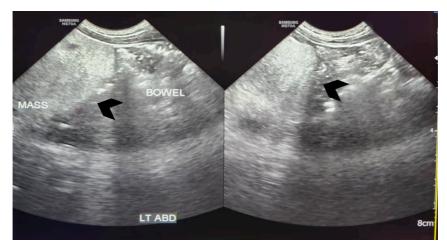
Abdominal ultrasound showed a large lobulated hyperechoic mass occupying abdomen and pelvis (black arrowhead)
